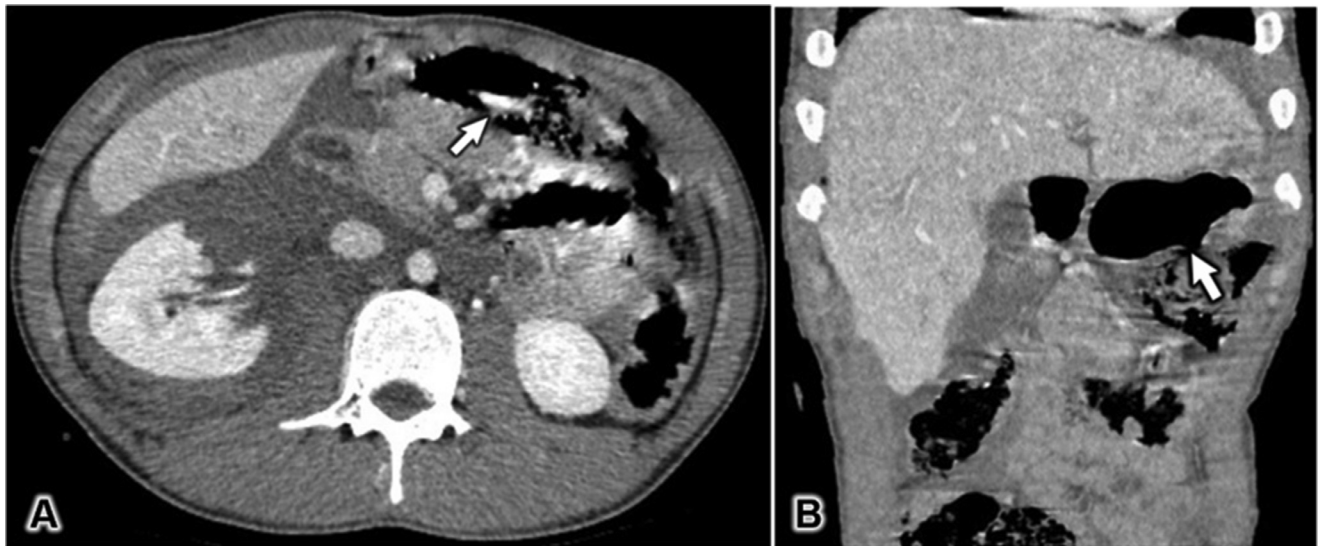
Pneumoperitoneum. (A) An axial image from the abdominal CT scan in the portal venous phase demonstrates free intraperitoneal air (arrow). (B) A coronal image from the post-contrast hepatic venous phase shows a discontinuity of the stomach wall and a connection with the free air (arrow), suggesting that this is the location of the rupture.
